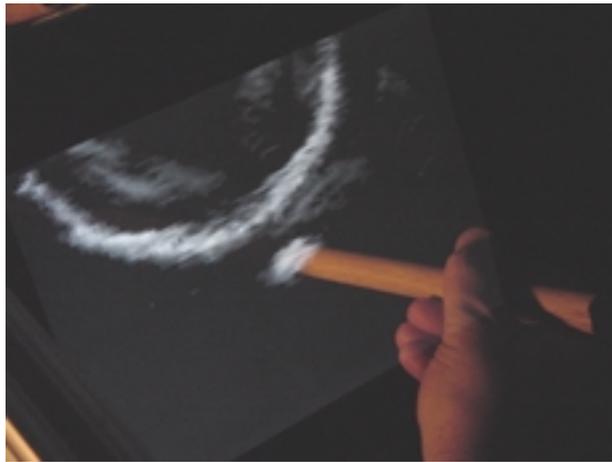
Mock effector* (3/4" wooden dowel) interacting with the virtual image of a magnified ultrasound scan of the balloon, seen through the half-silvered mirror.
